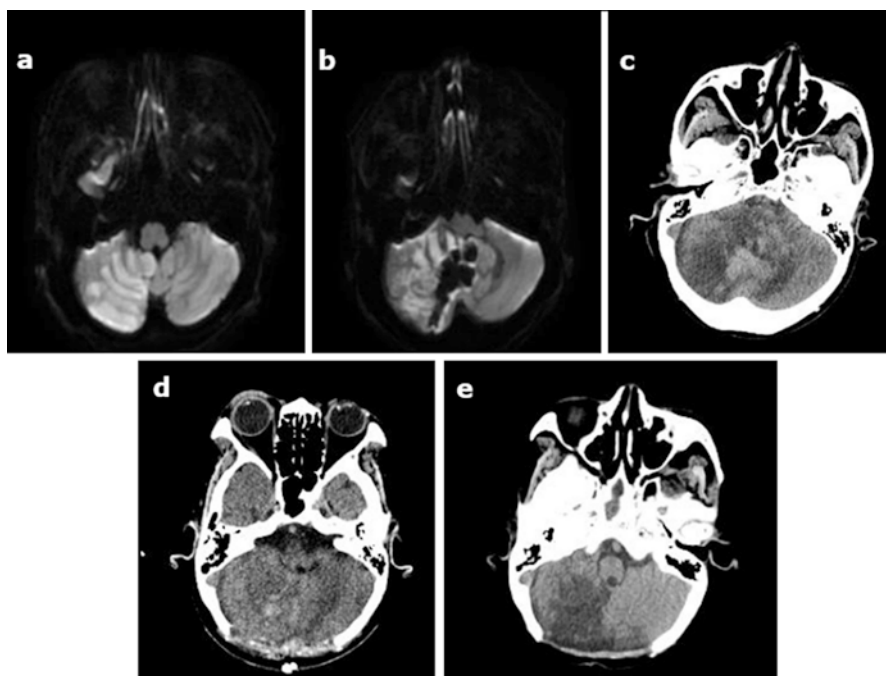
Space-occupying cerebellar infarction. Brain MRIs show acute infarction in the right PICA territory (a) and hemorrhagic transformation in the infarcted area 1 day later (b). Brain CT images (c–e) show serial changes of brainstem compression resulting from cerebellar infarction. This patient underwent decompressive surgery due to brainstem compression (c: before; d: after). The alteration in the consciousness and respiratory depression was improved with resolution of brainstem compression (e: 1 week after decompression)
